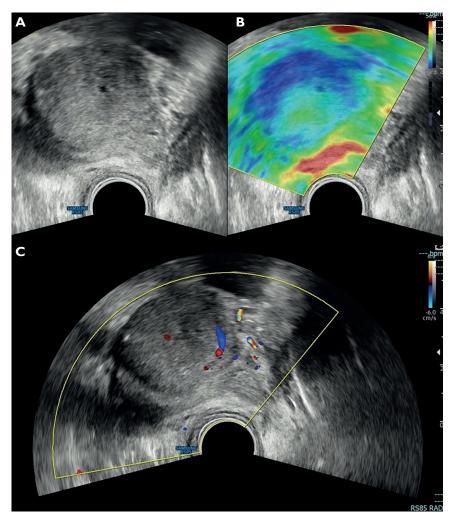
(A-C) Transrectal ultrasound confirmed the presence of a voluminous prostatic mass (A), with solid component showing intense blue colour on elastographic evaluation (B) and intralesional vascularization on colour Doppler evaluation (C), highly indicative of malignancy.
